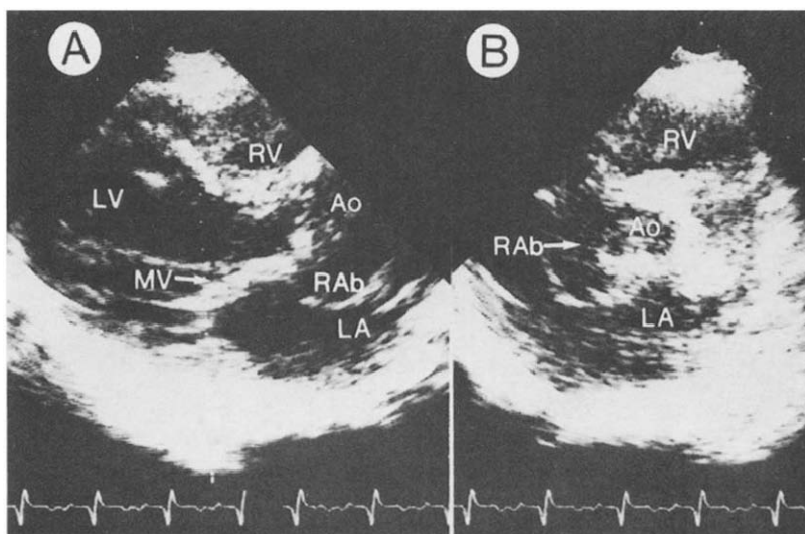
Case 1. Two-dimensional echocardiogram in a patient with a Björk-Shiley aortic valve prosthesis. A, Parasternal long-axis view in systole shows an echo-free space that corresponds to the valve ring abscess (RAb). It is posterior to the aortic (Ao) anulus and encroaches on the left atrium (LA). Valvular vegetations are not seen. B, Parasternal short-axis view shows that the valve ring abscess (RAb) involves the right coronary anulus. LV = left ventricle; MV = mitral valve; RV = right ventricle.
